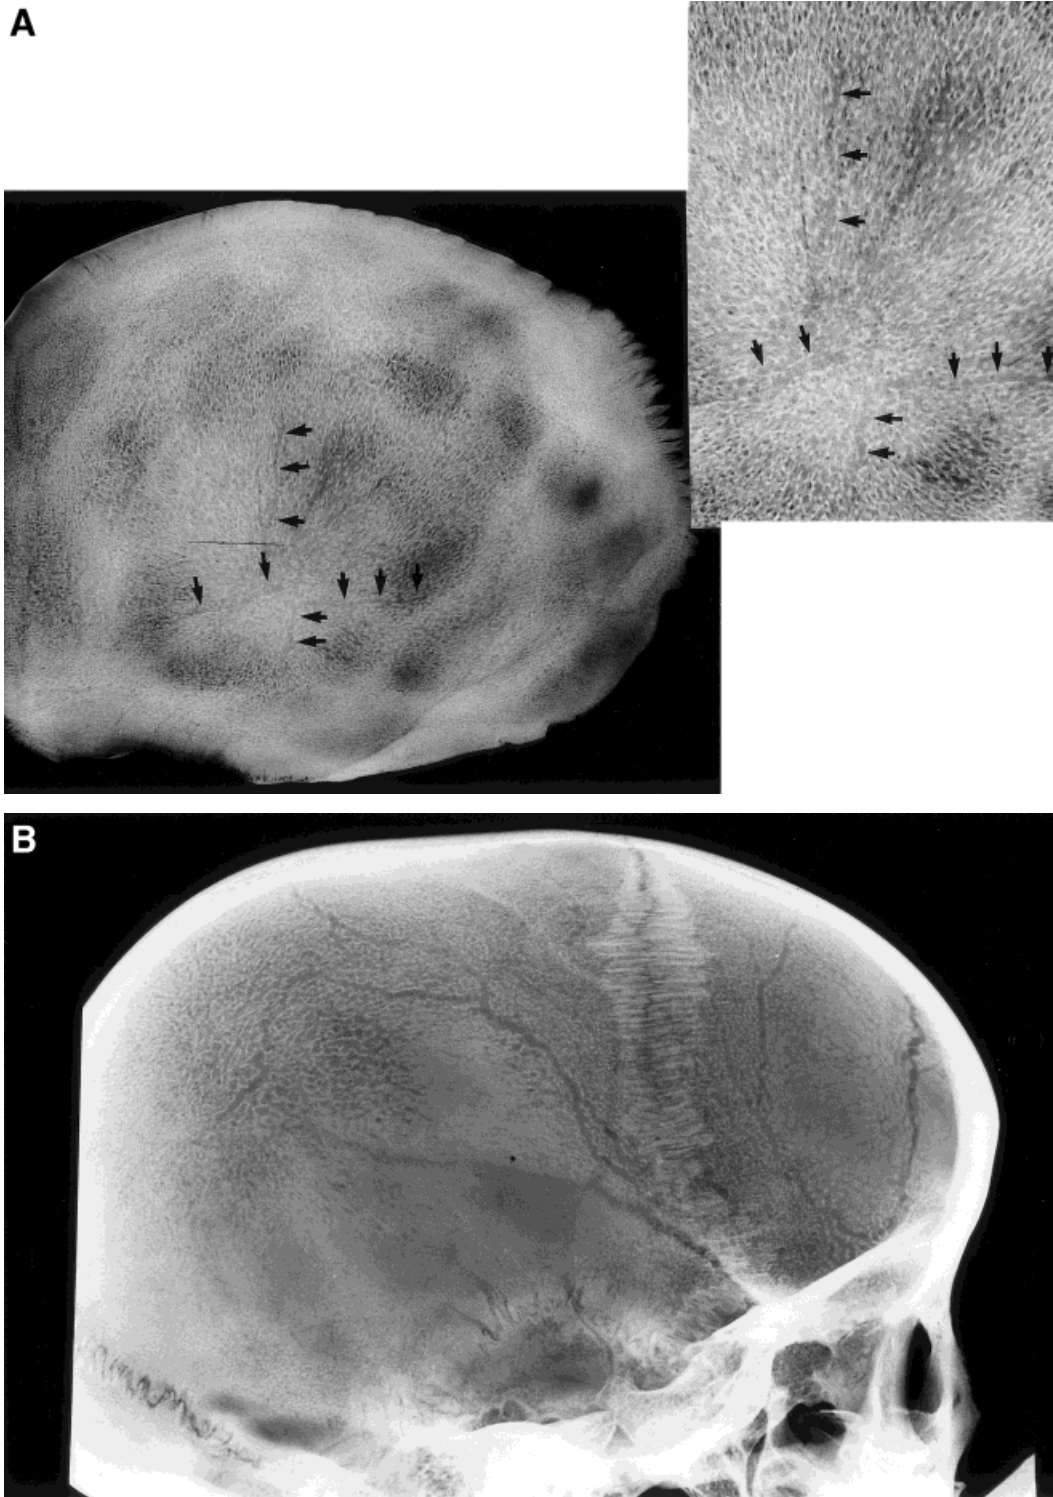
Lateral x-ray view revealing presence of diploic veins. A: Seven-month-old fetus. Arrows indicate early diploic vein development. B: Four-year-old.
